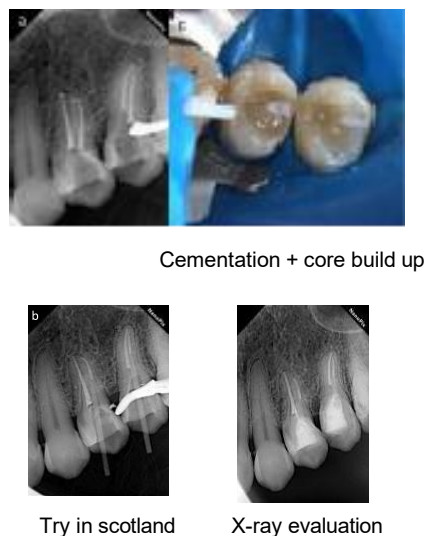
a) Root canal obturation b) Evaluation of fiber stake try in using periapical radiography c) Stake cementation and Core build up d) Evaluation of periapical X-rays.
